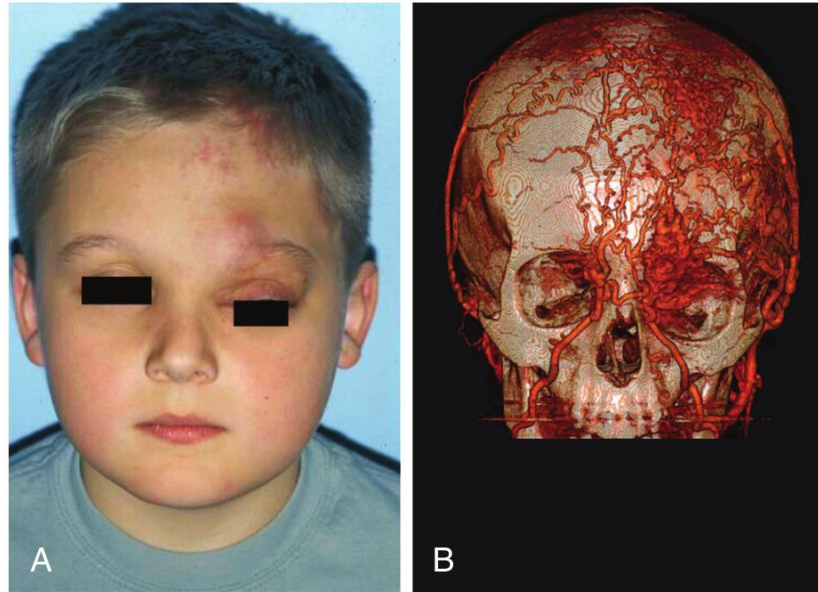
Extensive vasodilation associated with enlarging orbital/eyelid arteriovenous malformation. A, Clinical appearance. B, Computed tomographic angiography image with nidus in orbit and extensive vasodilatation. (A, Courtesy Dr. J. Gruss.)
